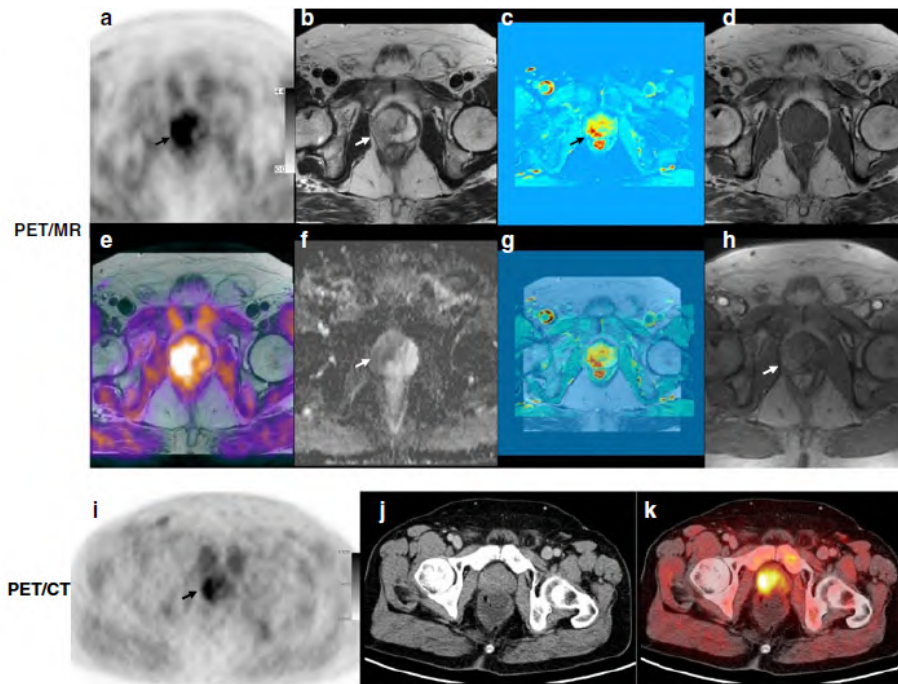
$^{11}\text{C}$ -Choline PET/CT and PET/MR images of a 66-year-old patient with prostate cancer proven by biopsy. The images were performed consecutively using one injection. The black arrows in (a) and (i) show an increased focal  $^{11}\text{C}$ -choline uptake in the right side of the prostate, which suggests prostate cancer. On the different MR images, a lesion is seen in the right peripheral zone: a hypointense signal on the T2-weighted sequence (b), high ADC values (and therefore low signal) on the diffusion weighted image (f) and hypervascularity in the DCE image (h). The T1-weighted image in (d) did not show any evidence of haemorrhage. (e) shows the fused image of the PET and MR modalities. In (k) the fused image of PET and CT is shown while in (j) the CT image is shown. Note that the tumor cannot be differentiated from the CT image alone. [29]
